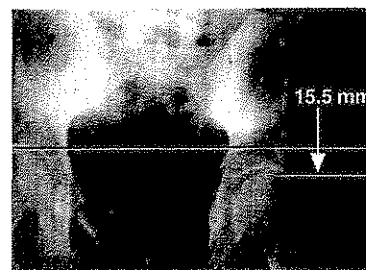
X-ray of an unlevel pelvis with typical rotation patterns.
